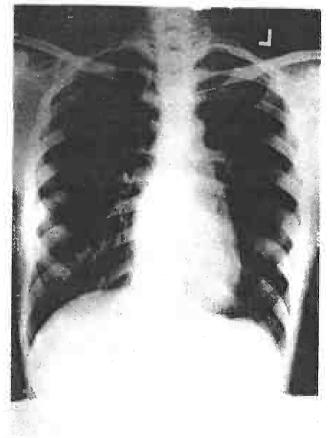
Chest Xray of Case 3 taken 2 weeks after admission following vigorous treatment for heart failure. The heart size is now normal and the lung fields are clear.
